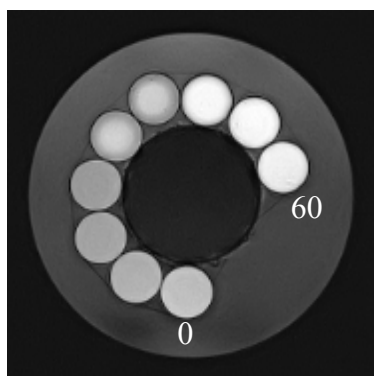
FLAIR image at TI = 1500 msec.
